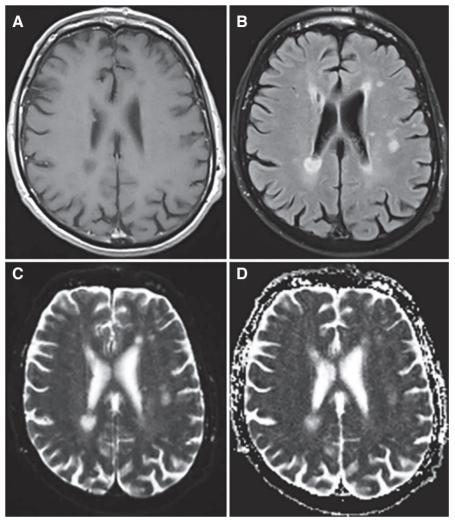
MRI Brain at the presentation showing multiple areas of hypointensity within the subcortical white matter on TI (A; without gadolinium enhancement), hyperinstensity on T2 (B) and only T2 shine-through on diffusion-weighted imaging (C) and no true abnormally-restricted diffusion on ADC (D) at this stage. The appearances raised the suspicion of an underlying ischaemic or inflammatory process. Spinal cord imaging was unremarkable
